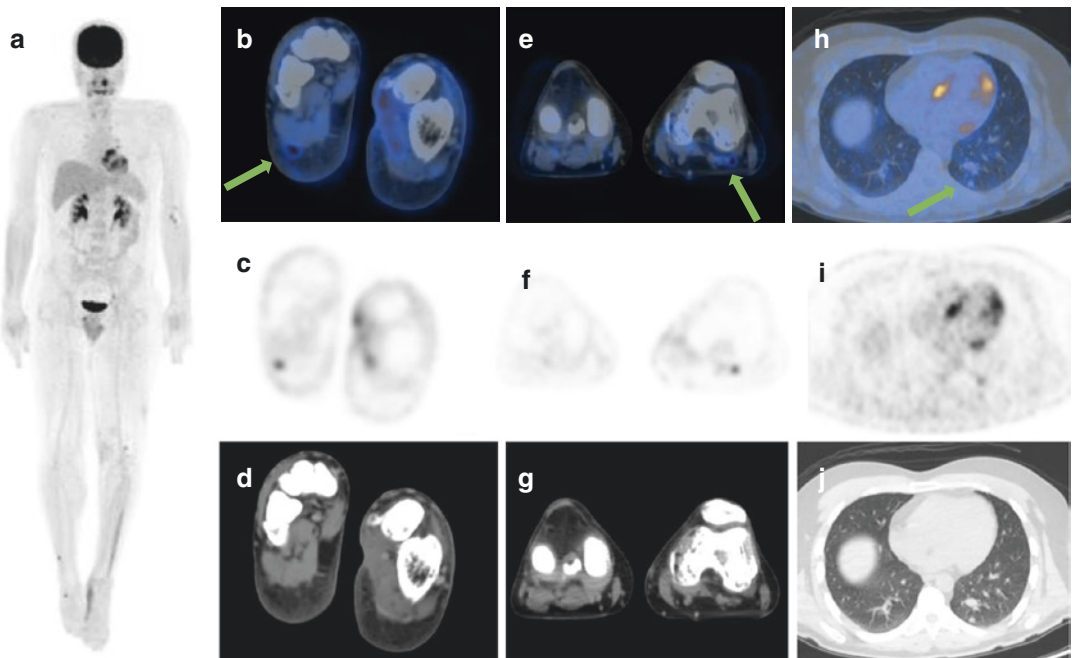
(a) Staging FDG PET/CT scan: Mass characterized by abnormal increased uptake at the left foot ( $SUV_{max} = 15$ ; b–d) and within popliteal ( $SUV_{max} = 14$ ;
